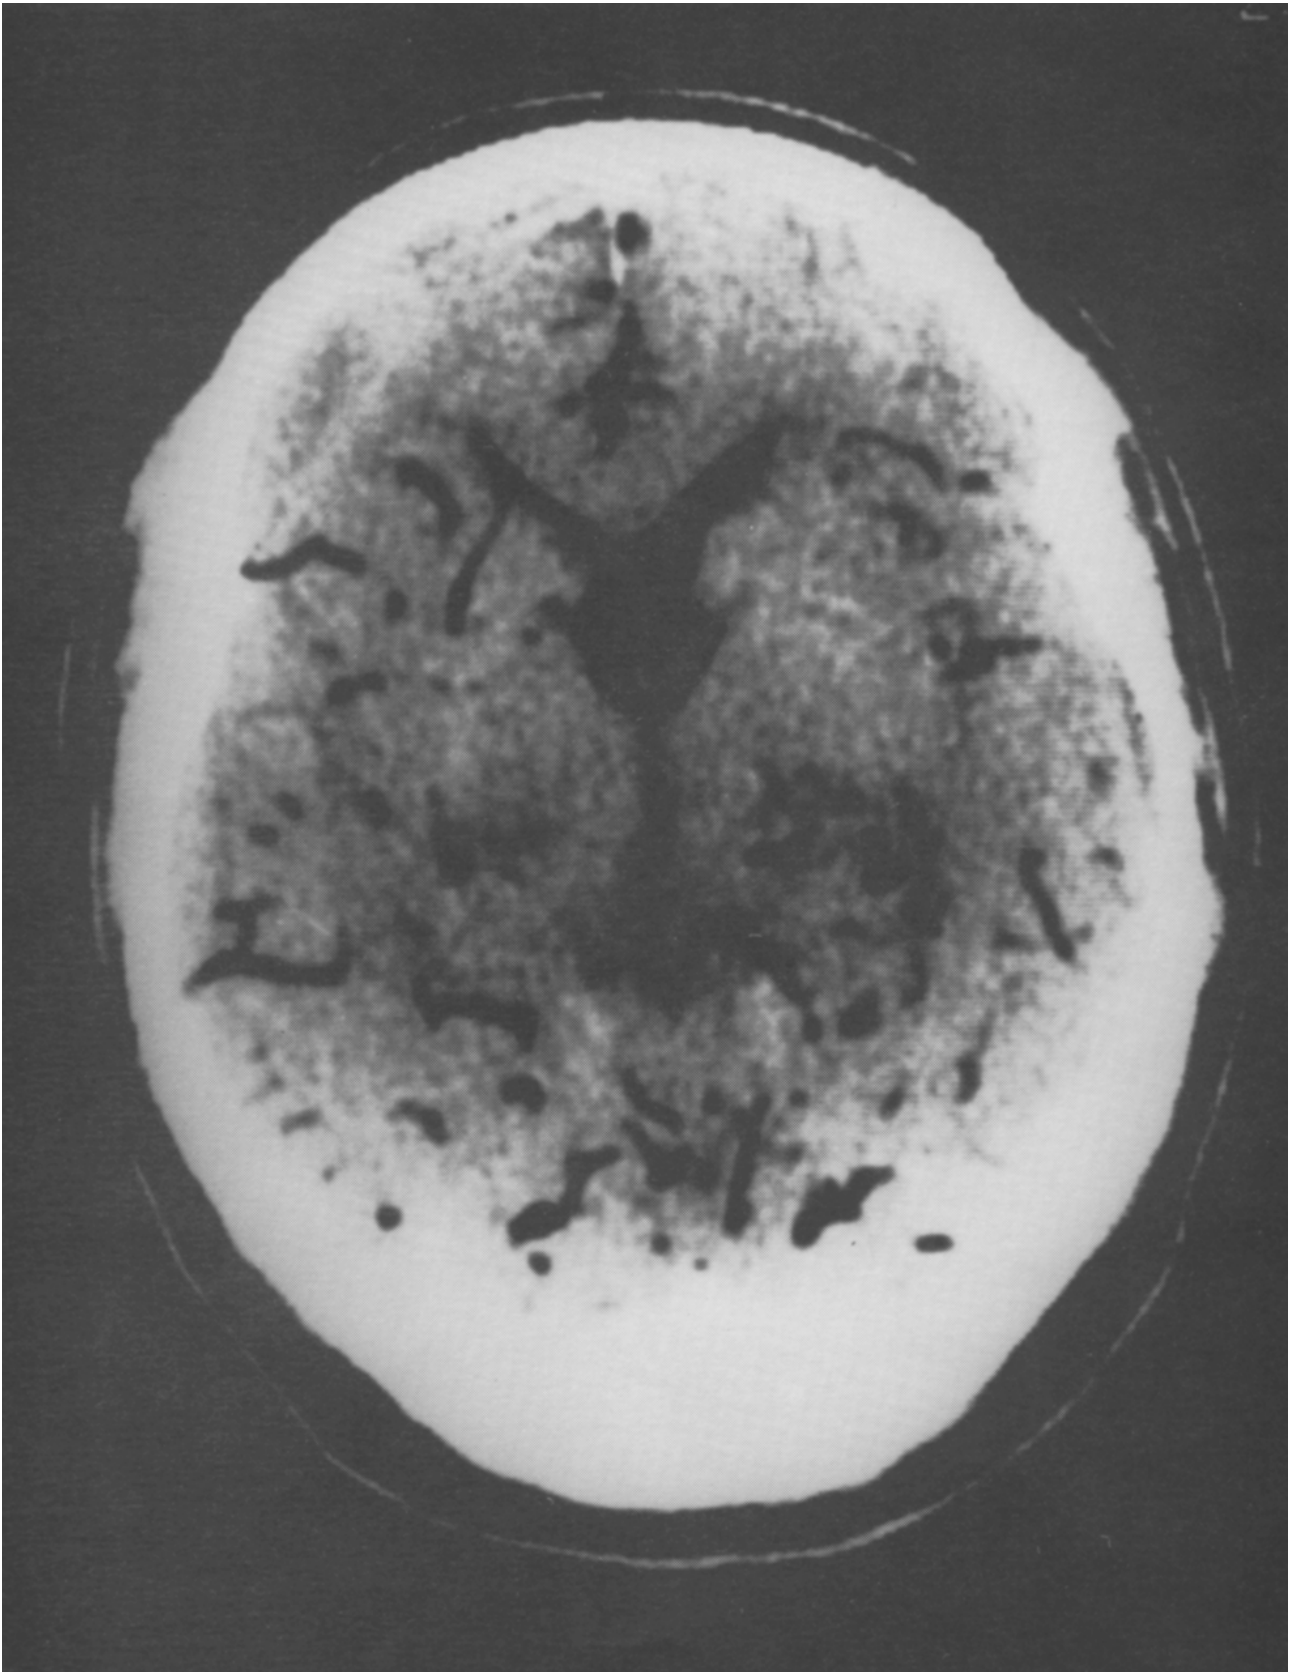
Post-mortem CT scan of Case 2.
